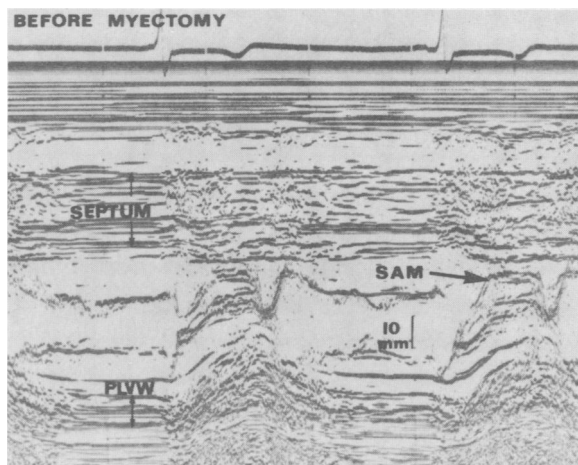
Preoperative echocardiogram of mitral valve and left ventricle. Shown are the mitral valve with systolic anterior motion (SAM) and asymmetric septal hypertrophy (septum/posterior left ventricular wall [PLVW] ratio=2.4). These findings are characteristic of hypertrophic cardiomyopathy with obstruction. Shown is a 10 mm calibration.
